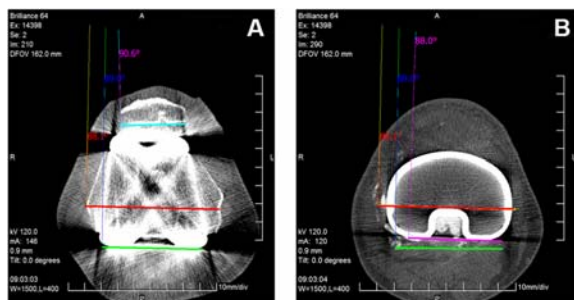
CT digital images were evaluated with the knee in full extension. The transepicondylar axis (red line), femoral component (green line) and patellar component (blue line) rotational alignment were drawn (A). The tibial component rotational alignment (purple line) was drawn and then superimposed on the transepicondylar axis and femoral component rotational alignment to determine the femoro-tibial rotational mismatch (B).
